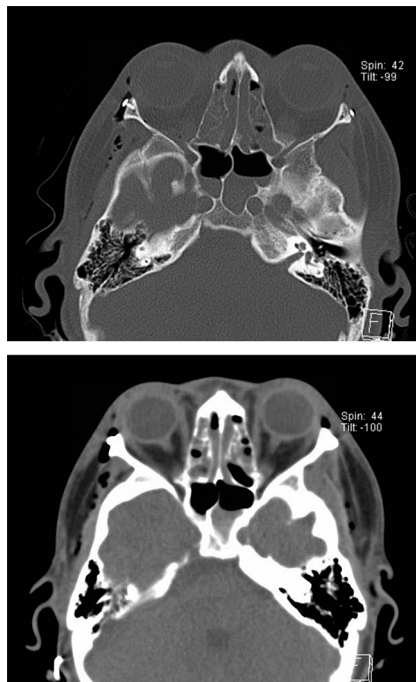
Intraoperative CT scan revealing no fracture or hematoma involving the right orbital apex or optic canal.
